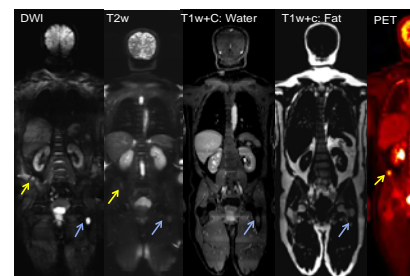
Metastatic lesions in the right iliac bone (yellow) and left femur (blue) are best depicted on DWI.
